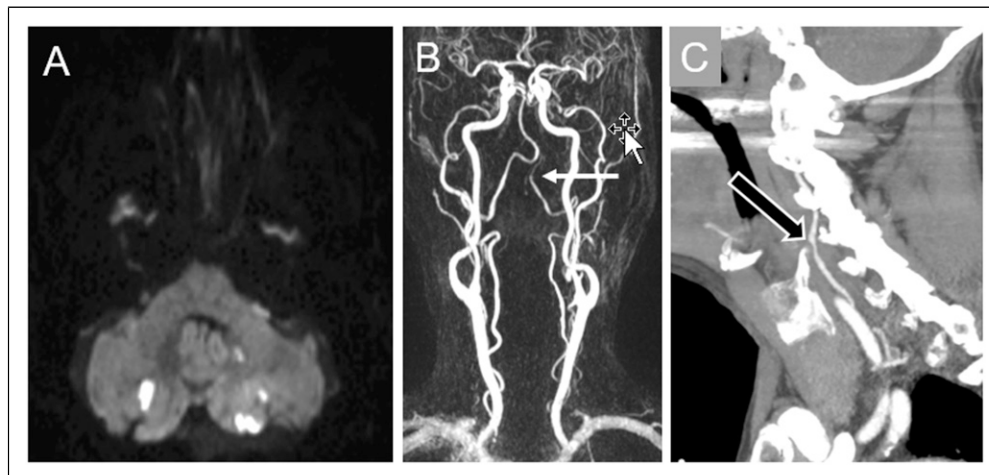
Case no. 5. (A) DWI-MRI showing acute bilateral strokes in the posterior inferior cerebellar artery territory. (B) Compression of the fourth segment of the left vertebral artery (arrow). (C) Direct contact between the ossified posterior horn of the thyroid cartilage (black arrow) with the left vertebral artery.
